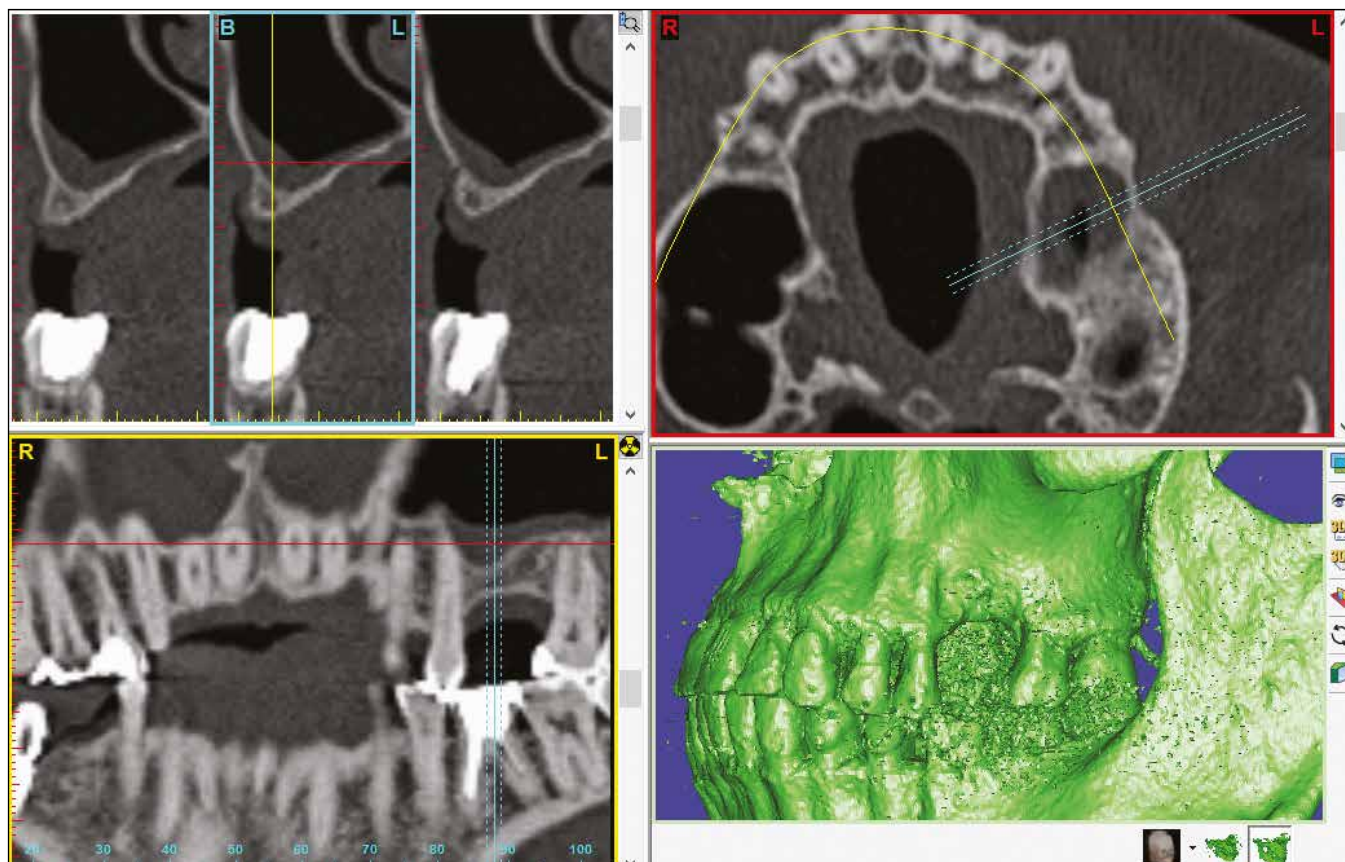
Fragment of computed tomography of the upper jaw of the 44-year-old male patient T., case record No.471. Diagnosis: edentulism of the upper jaw, Kennedy Class III. Thickening of the mucous membrane of the left maxillary sinus in the projection of extracted tooth #16 associated with chronic granulating periodontitis.
